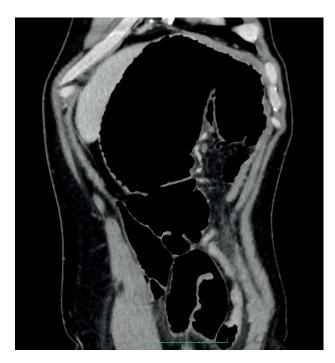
(a): sagittal abdominal CT scan showing the appendix and the dilated cecum in the left hypochondrium
